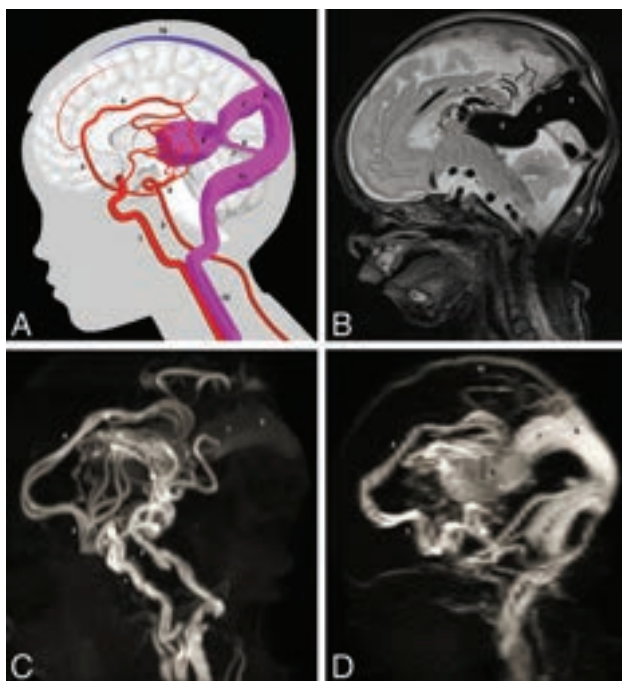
Scheme and MR imaging of a VGAM. A, Simplified scheme of VGAM. B, Sagittal T2-weighted MR image. C, Arterial TOF-MRA. D, Venous TOF-MRA. 1) internal carotid artery; 2) basilar artery; 3) anterior cerebral artery; 4) pericallosal artery; 5) posterior cerebral artery; 6) dilated MPV; 7) falcine sinus; 8) straight sinus; 9) accessory confluence; 10) SSS; 11) transverse sinus; 12) internal jugular vein.
